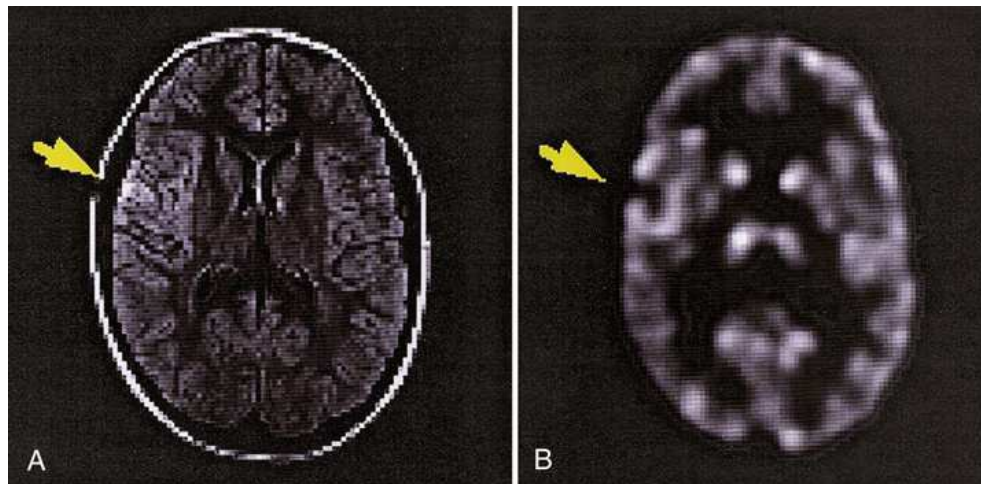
Coregistered MRI and PET scans. Arrows indicate an abnormality on the anatomic image (A, MRI scan) and the functional image (B, PET scan). ^{18}F -FDG PET image depicts hypometabolic area of seizure focus (arrow) in a patient with a diagnosis of epilepsy.
